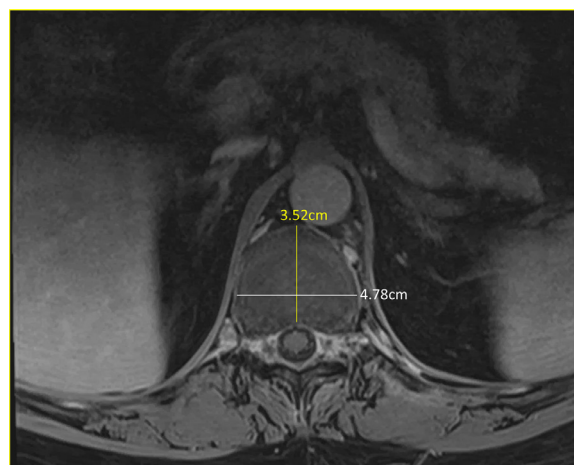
Axial T1 MRI Thoracic Spine Post-Gadolinium: superior endplate of the caudal T11 vertebral body indicating larger footprint of reconstruction required during VBR.
